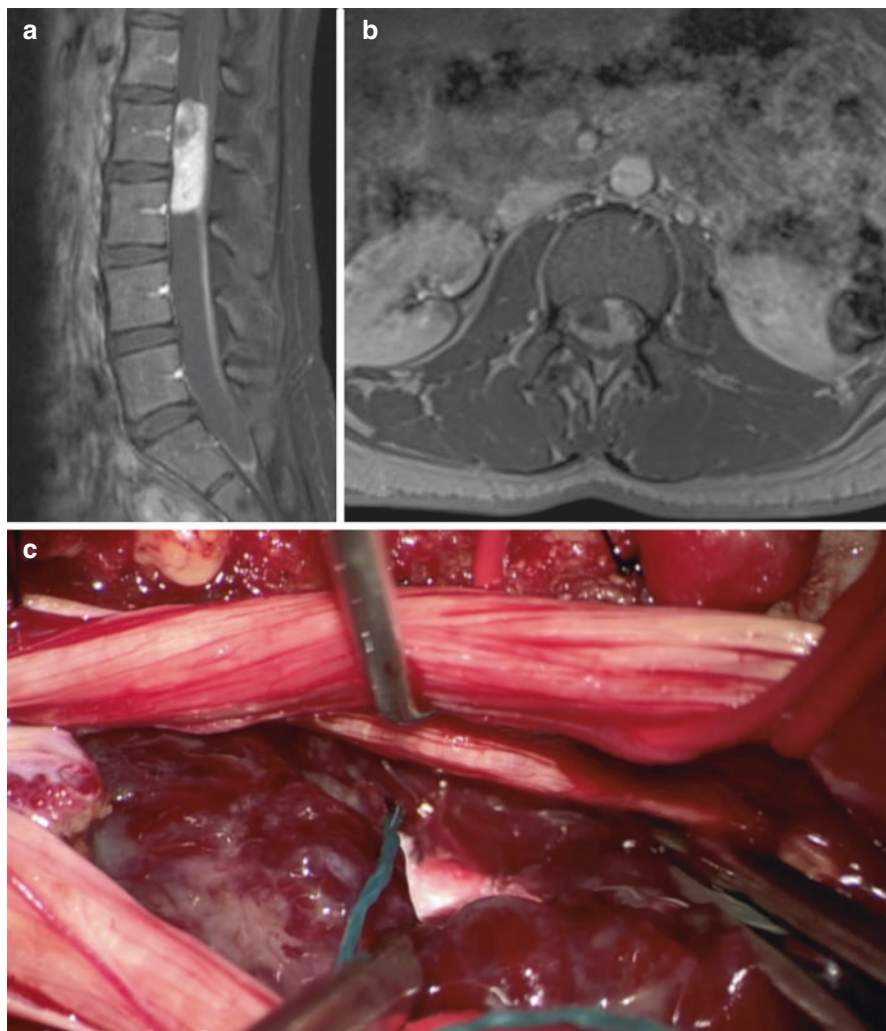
Myxopapillary ependymoma of the lumbar region in a 52-year-old man who presented with worsening urinary incontinence and numbness in the legs. (a, b) T1-weighted MRI images with gadolinium suggested a myxopapillary ependymoma. (c) The tumor was debulked with preservation of the nerve roots
